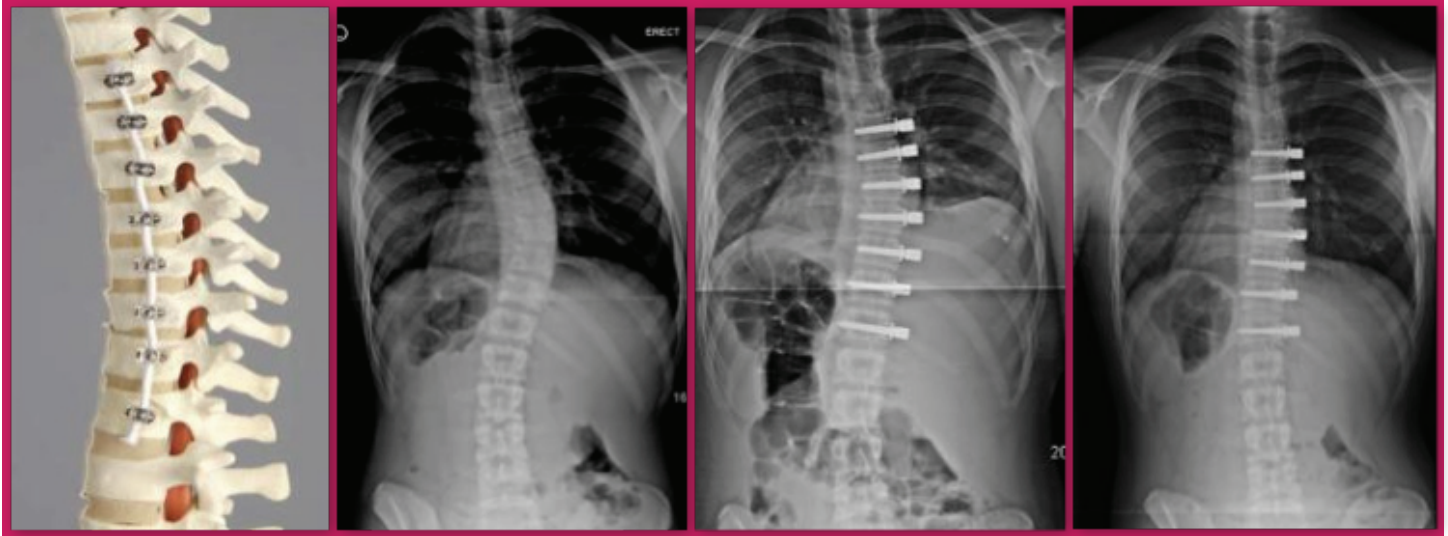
a) sagittal view of a spine model with intact pedicle screws and PET tether. b) 14yo girl with 38° thoracic scoliosis. c) 1st post-op X-Ray with residual curve 25° d) 2 years post-op with residual curve of 6°.
